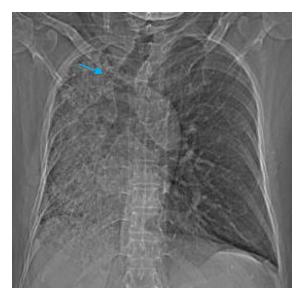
CT topogram showed reticular opacities in the right lung with volume loss, tracheo-mediastinal shift to the right (blue arrow)
